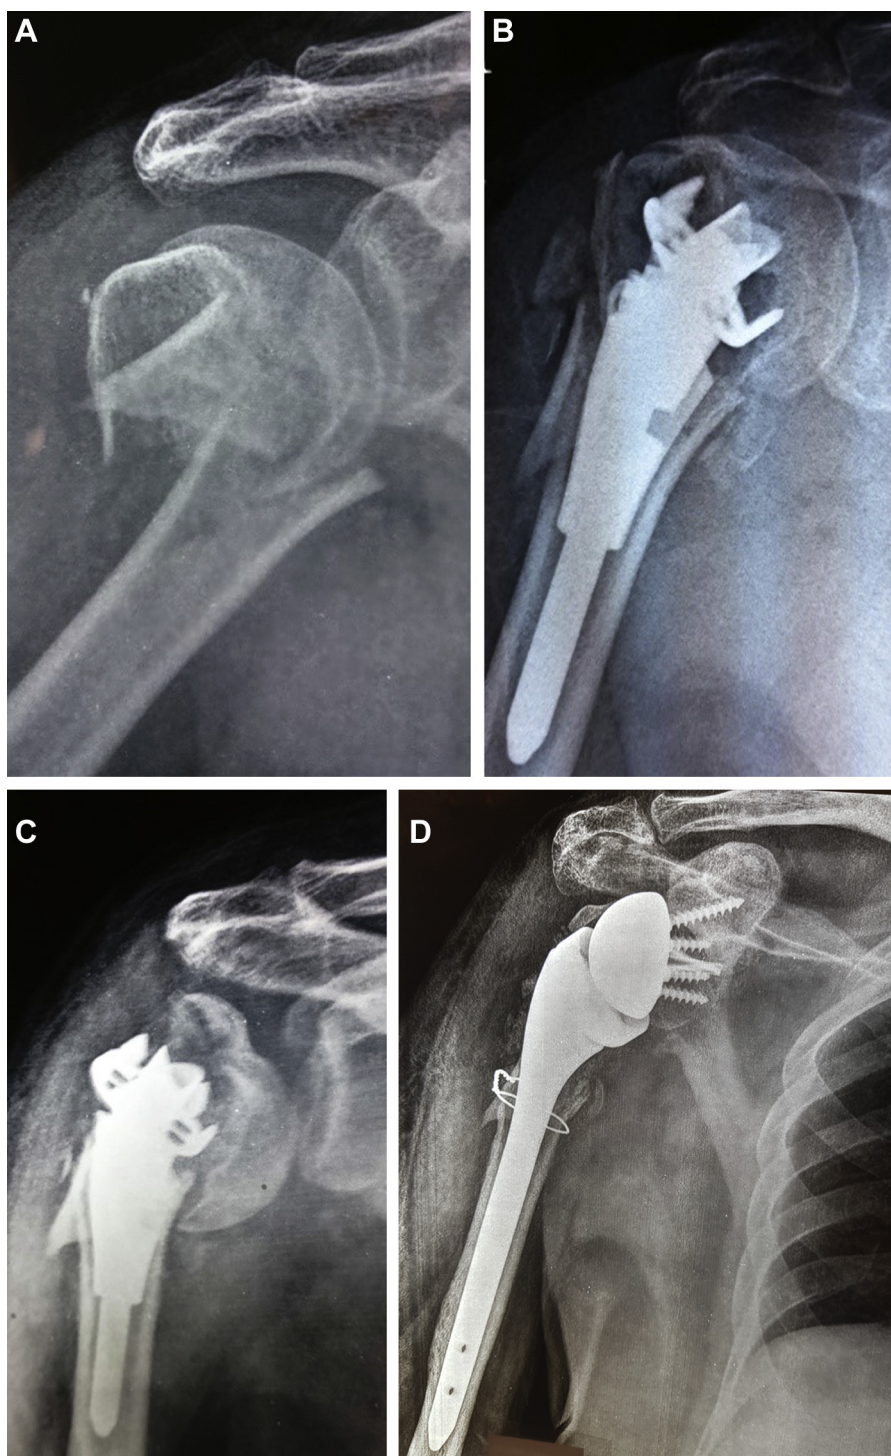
(A) Displaced 4-part proximal humeral fracture with large butterfly fragment on preoperative anteroposterior radiograph. (B) Postoperative anteroposterior radiograph showing well-placed implant but unattended butterfly fragment. (C) Two-month follow-up anteroposterior radiograph depicting unstable stem and varus collapse of humeral head. (D) Immediate postoperative radiograph following revision to reverse shoulder arthroplasty.
